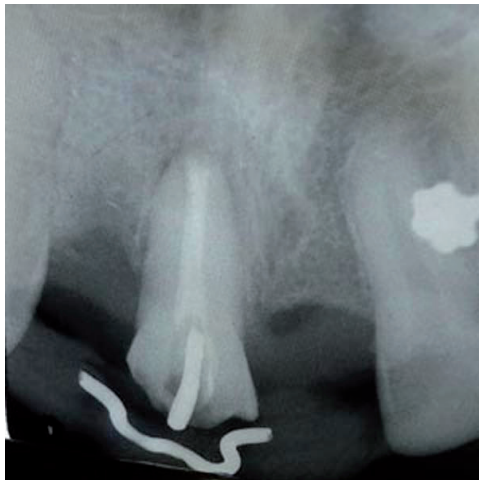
IOPA radiograph of extruded tooth
